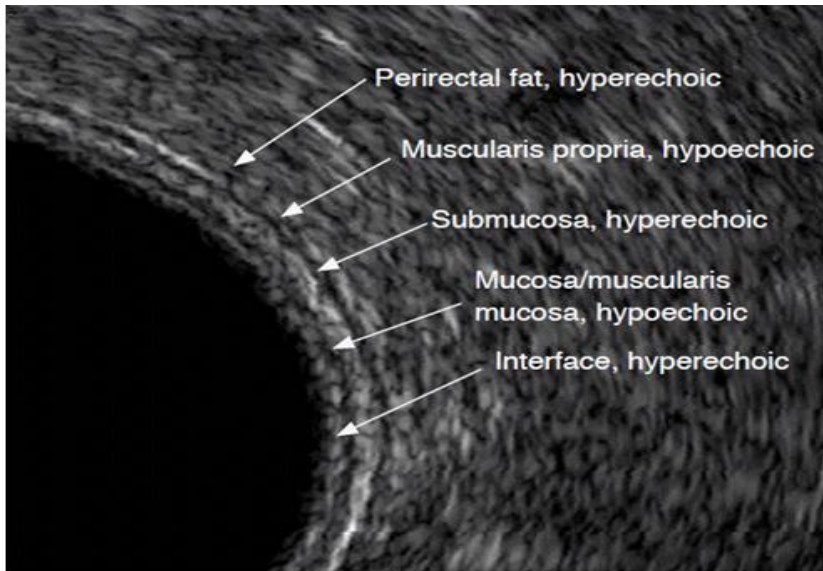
3 Normal rectal wall layers in USG (Source:ultrasonography.org)
